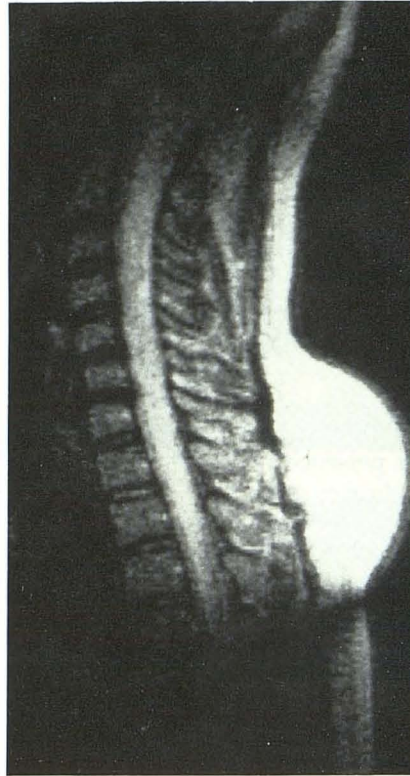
Spin-echo T2-weighted MR image (TE 100, TR 1700) using a spine coil shows diffuse increase in signal throughout enlarged spinal cord. Spin-echo T1-weighted images (TE 35, TR 600) revealed only cord enlargement.
